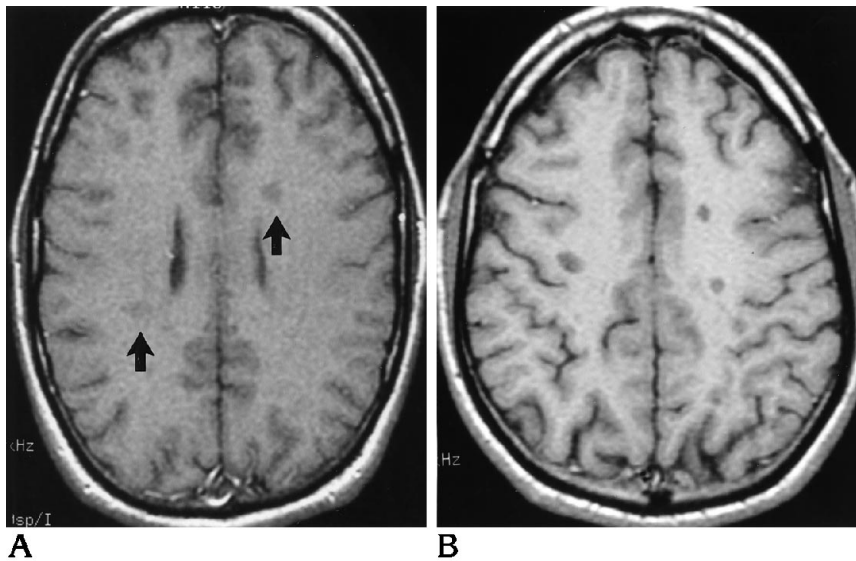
Examples of white matter lesions on T1-weighted images in two patients with multiple sclerosis.
